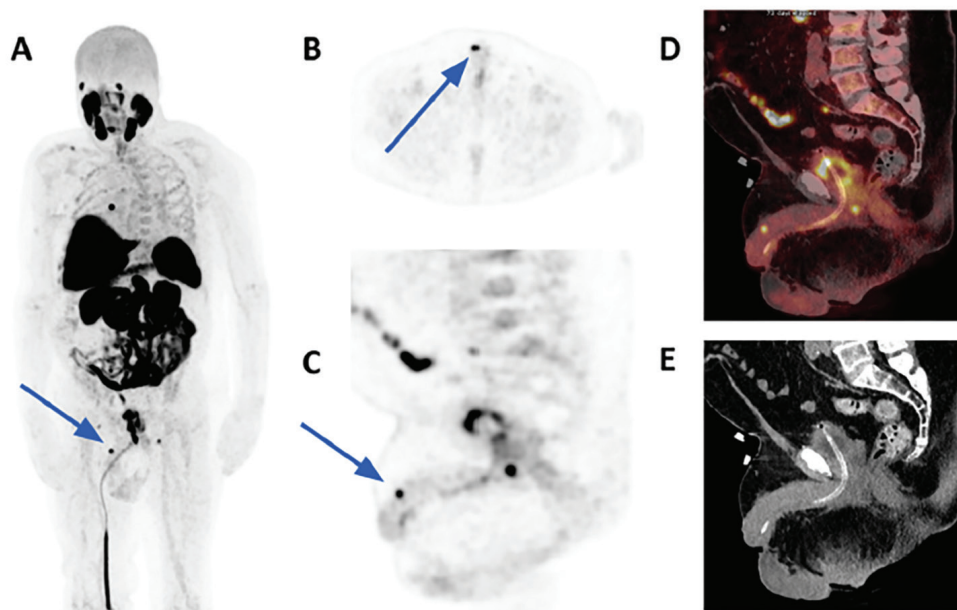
A 74-year-old man presents with recurrent prostate cancer and a prostate-specific antigen (PSA) level of 10 ng/mL (A) The left anterior oblique maximal intensity projection of ^{18}F -fluorodeoxyglucose, positron emission tomography/computed tomography (PET/CT), demonstrates prominent heterogeneous prostatic activity with intense focal activity in the right peripheral zone. A focus of uptake in the distal penile shaft was also seen (arrow). Axial, sagittal ^{18}F -prostate-specific membrane antigen (PSMA)-1007 PET and sagittal fused PET/CT (B, C and D) demonstrate the subcentimetric focus of tracer uptake in the right side of the penile shaft (arrows), which is not due to urinary contamination. Sagittal low-dose non-contrast CT (E) does not show an appreciable soft tissue lesion. ^{18}F -PSMA-1007 PET is fast becoming a key imaging modality in the assessment of biochemically recurrent prostate cancer (1), which can occur in up to 27% of patients who are managed by radical prostatectomy, and up to 55% of those managed by radiation therapy (2). A recent meta-analysis found that although the detection rate (DR) of ^{18}F -PSMA-1007 PET is dependent on serum PSA values, there is a good DR even at low PSA levels (0.5 ng/mL) (1). As expected, local relapse, regional lymph node, distant lymph node, and bone metastases are the most frequent sites of metastases (1), with a significantly higher number of positive findings when compared to conventional CT (3). Penile metastases are rare, usually presenting as part of advanced disease, and indicate poor prognosis, with half of the patients dying within one year of diagnosis (4). The primary malignancies involved are predominantly urological (bladder and prostate cancers), but also, less commonly, gastrointestinal and lung cancers (4). Awareness of the penis as a rare site of metastasis is important to avoid misdiagnosis with other non-malignant conditions (5). Penile metastases can present clinically with malignant priapism and are detectable on PSMA PET/CT (6). Penile metastases from prostate cancer have also been detected on ^{18}F -choline PET (7,8).
